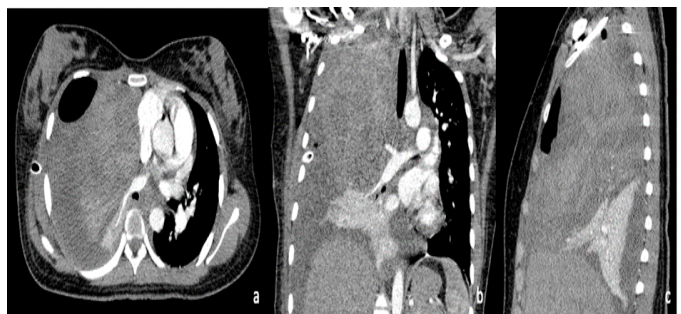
above shows axial (a), coronal (b), and sagittal (c) images of CT Pulmonary angiography. These images showed a heterogeneous hyperdense lesion confined to the right upper lobe, causing a mass effect to the right middle and lower lobes. Presence of heterogeneous hypodense collection with split pleural sign and pneumothorax, which has the attenuation of -73 to 133 Hounsfield Unit (HU).
